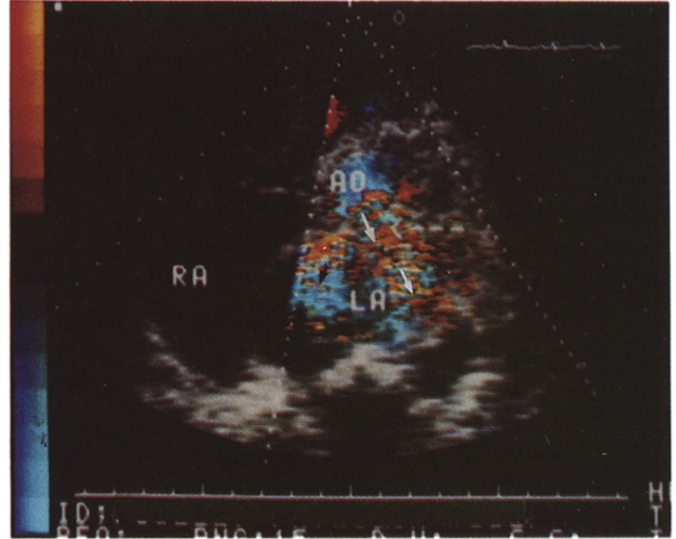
Color flow Doppler study of the same view as in Figure 1. The white arrows on the right side of the left atrium demonstrate turbulent flow (mosaic pattern) from the left ventricular outflow tract (labeled AO for aortic outflow) and the left atrium (LA). The small black arrow on the left side of the left atrium marks the area of mitral regurgitation.
